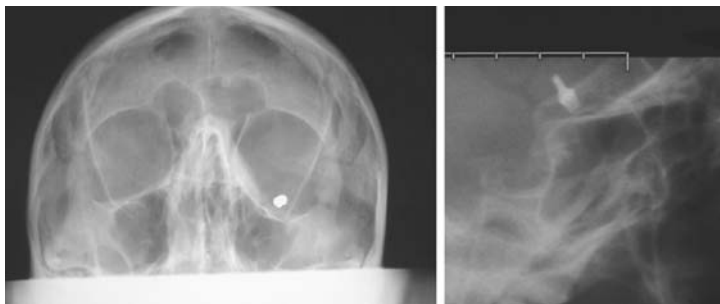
(left) An orbit x-ray taken as part of patient screening reveals this air-gun pellet. (right) This x-ray, taken to investigate a possible foreign body in the orbit, revealed an aneurysm clip from previous surgery.
